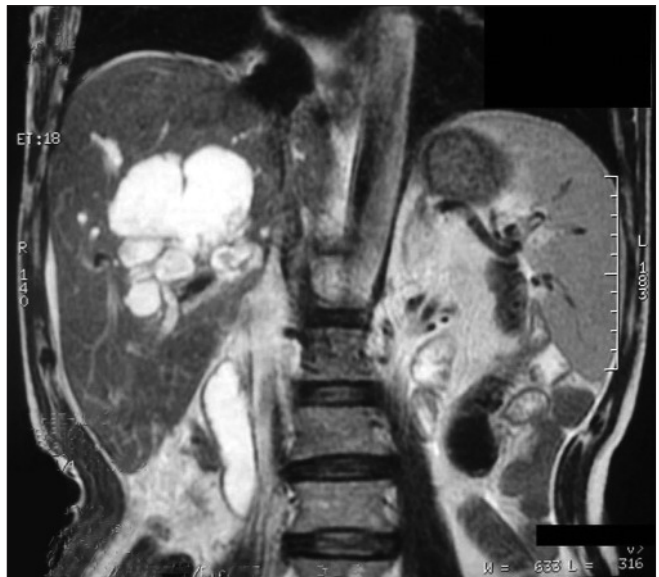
MRI appearance of the mass
